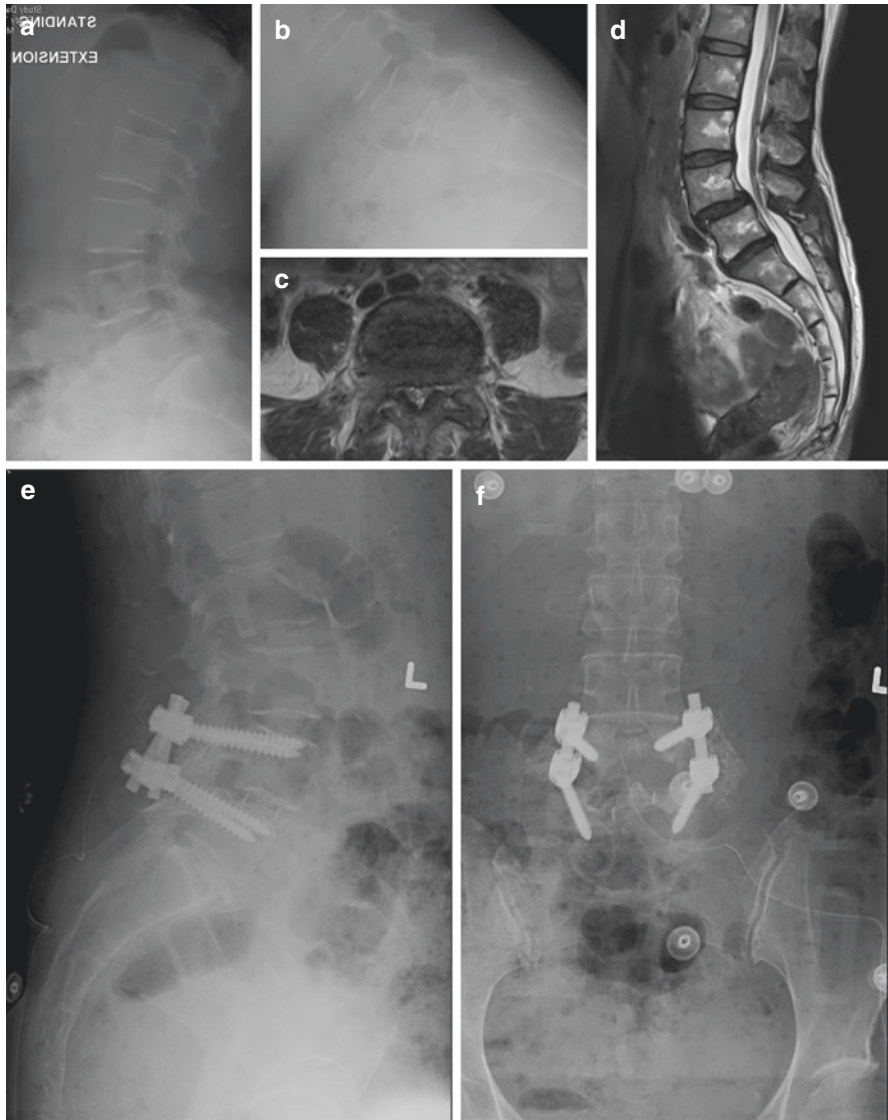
This patient presented with severe back pain and bilateral L5 radicular pain. (a and b) Extension and flexion radiographs demonstrating unstable L4/5. (c and d) Axial and sagittal T2-weighted MRI showing L4/5 spinal stenosis. (e and f) Postoperative radiographs after direct decompression, transforaminal interbody fusion, and posterolateral fusion
